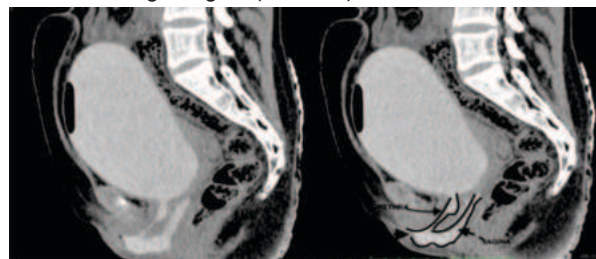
A and B): Sagittal section of CT cystogram showing posterior contrast filled vaginal tract joining the anterior urethral tract forming a common channel.
